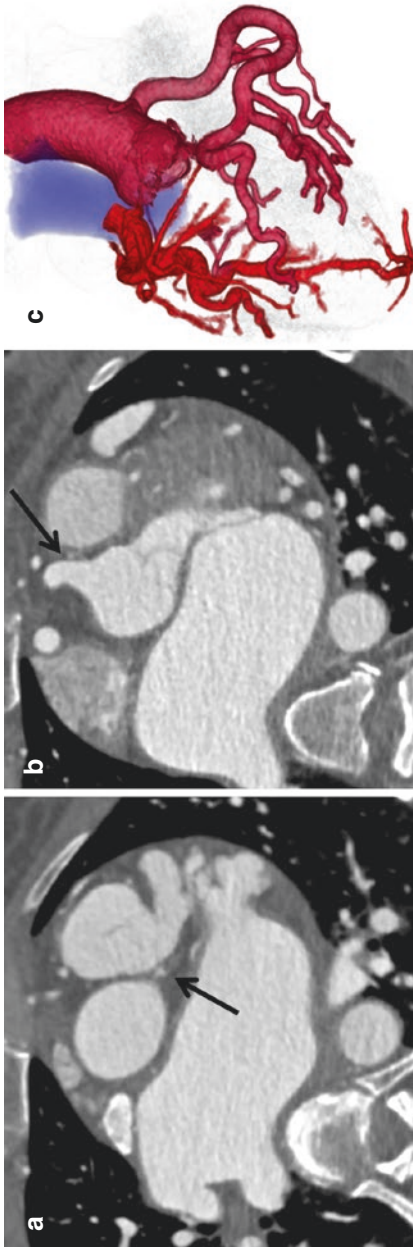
ALCAPA. Axial coronary CT angiography image (a) demonstrates the left coronary artery arising from the pulmonary trunk; the right coronary artery (RCA) arises normally from the aorta (b). Both coronary arteries are markedly dilated and tortuous, a global finding which is often well-demonstrated on volume rendered image reconstructions (c)
